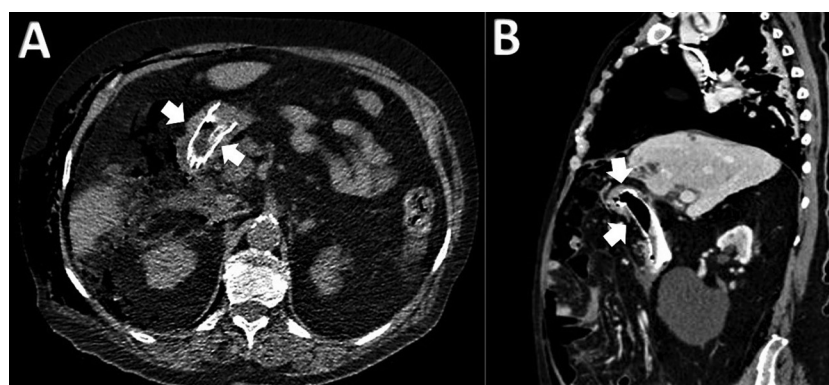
Computed tomography scan with water-soluble contrast medium assess the correct partially covered self-expandable metal stent deployment according to wall defect position. The arrows indicate the stent positioned in the duodenum in axial (A) and sagittal (B) scan.
